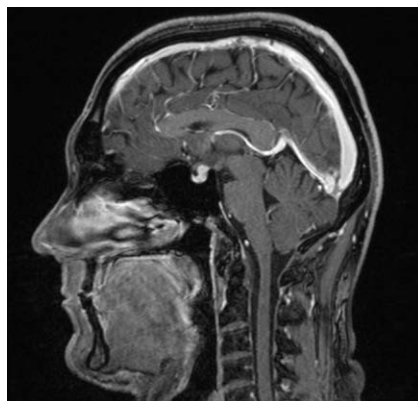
Contrast-enhanced T1w sagittal MRI image through the pituitary gland shows a Gadolinium-enhancing nodule at the dorsal aspect of the pituitary stalk.
